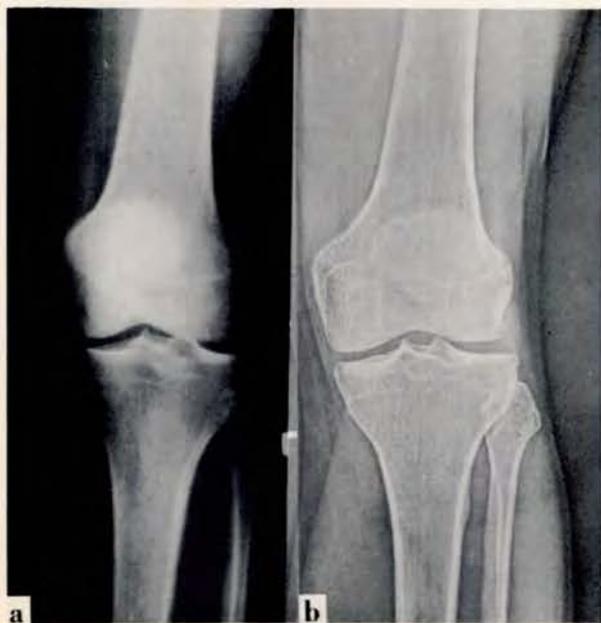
Same diver as in Fig. 1. Frontal projection of L knee on (a) conventional roentgenogram and on (b) xeroradiogram.
